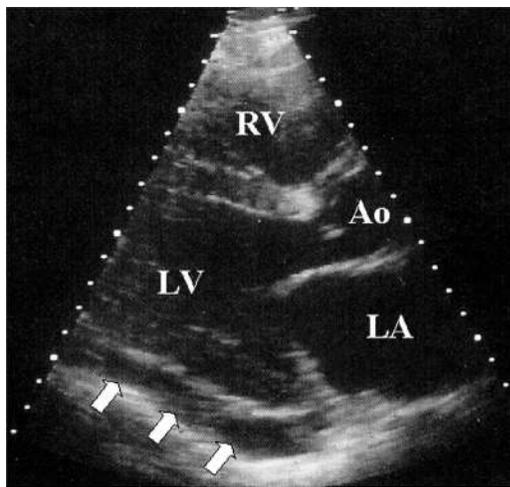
Echocardiographic findings in a small to moderate pericardial effusion (*white arrows*). Long-axis parasternal view. Ao, Aortic root; LA, left atrium; LV, left ventricle; RV, right ventricle.
